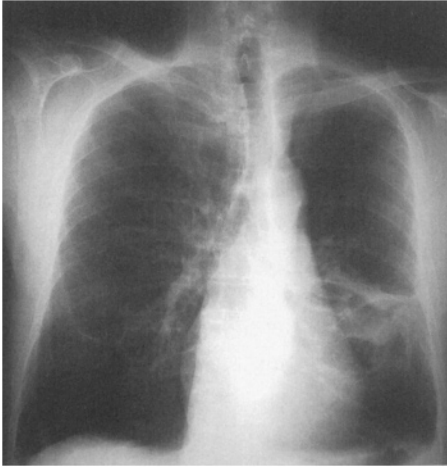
Plain chest radiograph : left visceral pleural thickening, with costophrenic angle obliteration and parenchymal bands
